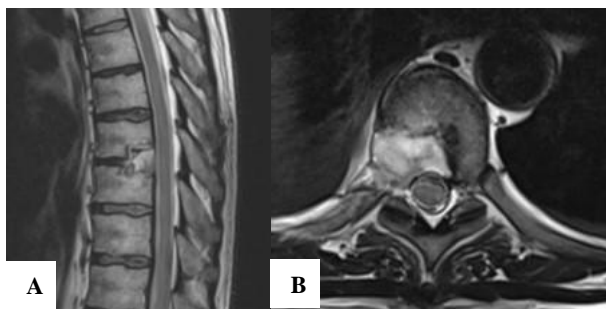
(A) Postop MRI sagittal view, (B) postop MRI axial view.
